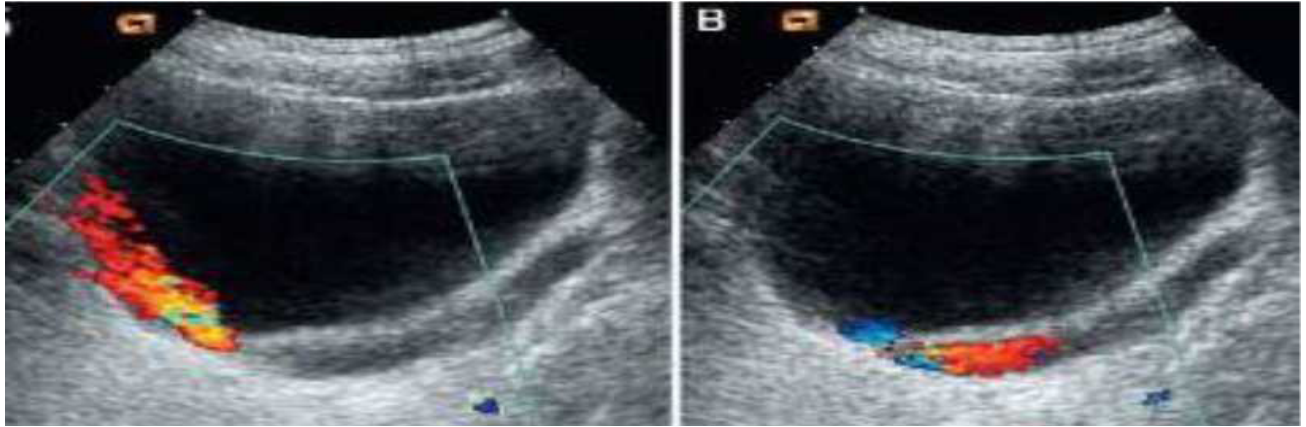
Dopplerographic Image of a Patient with Megaureter (MG)
